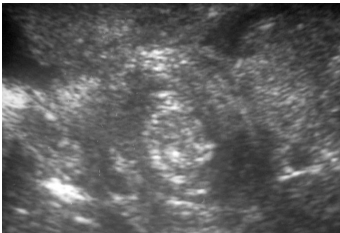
Ultrasound showing target sign
